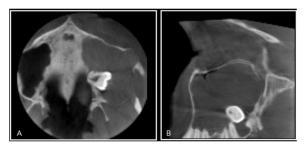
A large OKC in left maxilla. A&B: axial and sagittal scans of CBCT: Note to the molar tooth position and erosion in the lateral wall of maxillary sinus.
